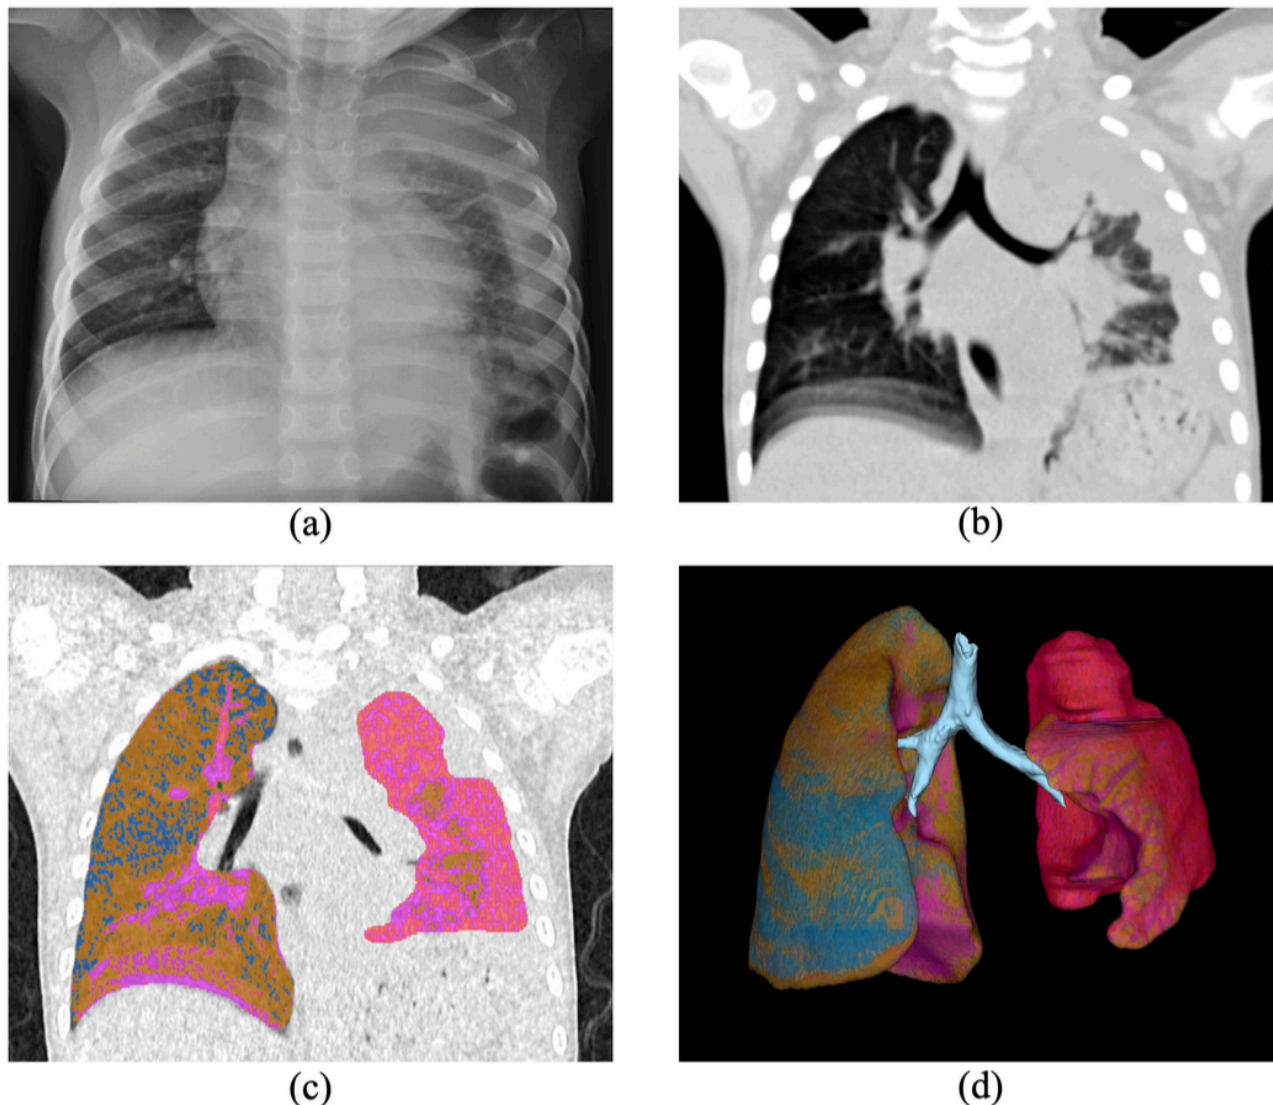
Multimodal imaging evaluation and AI-enhanced 3D reconstruction in a pediatric patient with pneumonia and parapneumonic effusion. (a) Chest radiograph showing retrocardiac airspace consolidation, concerning for left lower lobe pneumonia. (b) Coronal CT view of the thorax demonstrating multifocal left-sided airspace opacities with associated large parapneumonic pleural effusion. (c) Lung parenchyma segmentation using Lung CT Segmenter module in 3D Slicer (v5.8.1), highlighting affected lung zones. (d) AI-assisted 3D lung reconstruction using Lung CT Analyzer, showing volumetric distribution of aerated versus consolidated lung regions and pleural effusion. Light blue denotes the airway; dark blue represents normally aerated parenchyma; orange indicates areas of infiltration or inflammation; and pink represents regions of lung collapse.
